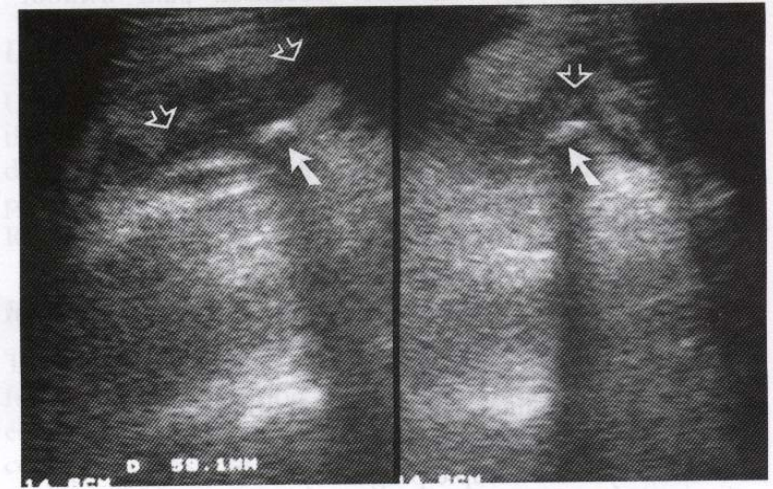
Abdominal ultrasound examination showing features of acute appendicitis, distended oedematous appendix (open arrows), longitudinal scan (left) and transverse scan (right). A faecolith is seen (closed arrow) (courtesy of Dr Michael Behan, Dublin, Ireland).
